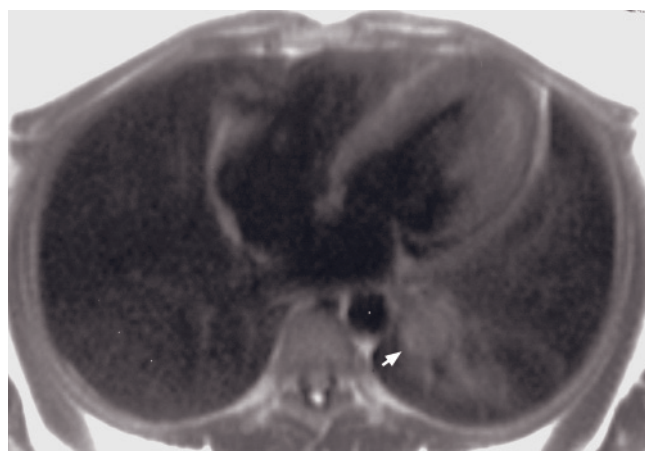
(Continued) image (g), coronal T1-weighted post-contrast 3D-GE images (b, i), and reconstructed 3D MIP image (j) in another patient with normal findings demonstrate lung parenchyma and vascular structures including pulmonary vasculature. Pulmonary arteries (thick arrows, f, i) and pulmonary veins (thin arrows, f, i) are shown. Minimal pulsation artifact over the right lung (e), which is due to cardiac pulsation, impairs the evaluation of lung parenchyma. However, transverse image shows there is no parenchymal abnormality in that region. Therefore, transverse and coronal images should be assessed together for the evaluation of lung parenchyma and pulmonary vascular structures.
